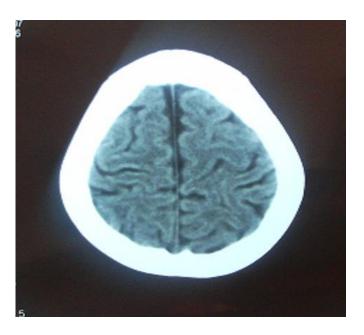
Subsequent CT of the patient in image (2) after recovery the sulci has recurred back
